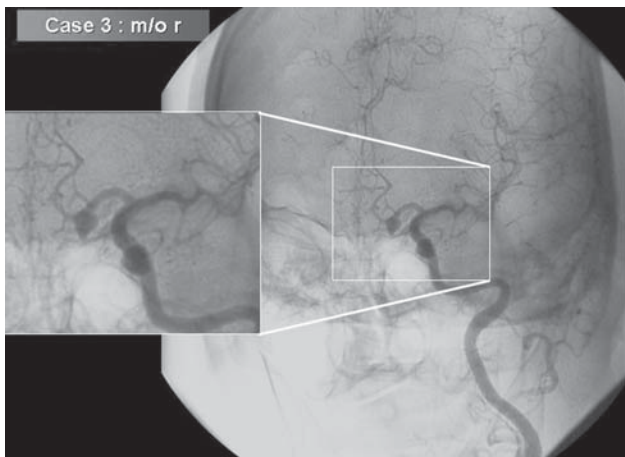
A 62 year-old woman presented with severe headache with loss of consciousness for 2 days. CT revealed subarachnoid hemorrhage. She was assessed as Grade 4 SAH. A diagnostic 3D rotational DSA showed a 7 mm aneurysm in the A1 segment of the anterior cerebral artery
